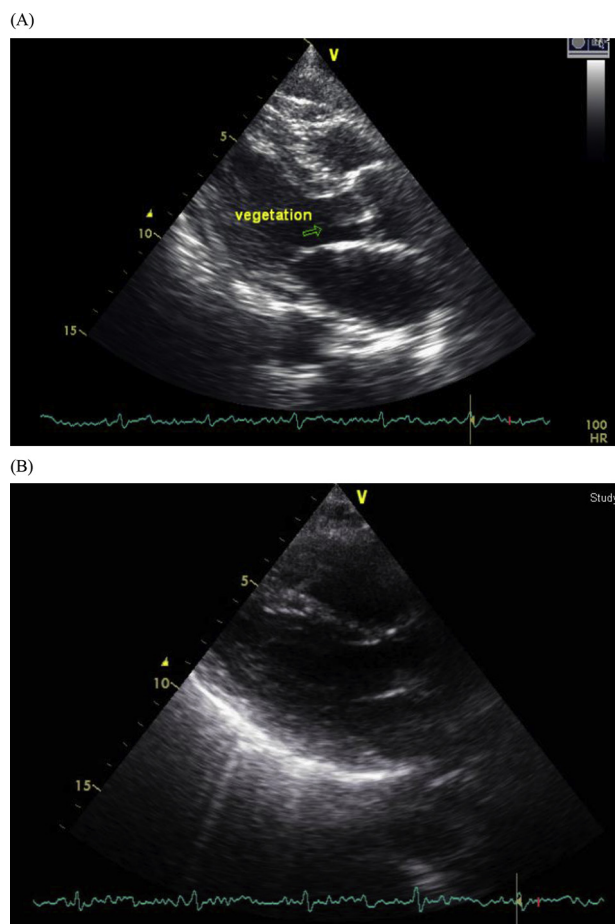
(A) A 13.8 mm × 4.4-mm aortic valve vegetation is noted in echocardiography. (B) There is no evidence of vegetation in the follow-up echocardiography.
